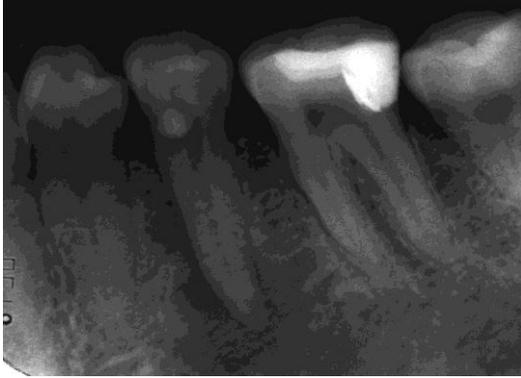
The periapical radiograph of the tooth #35 before endodontic treatment
